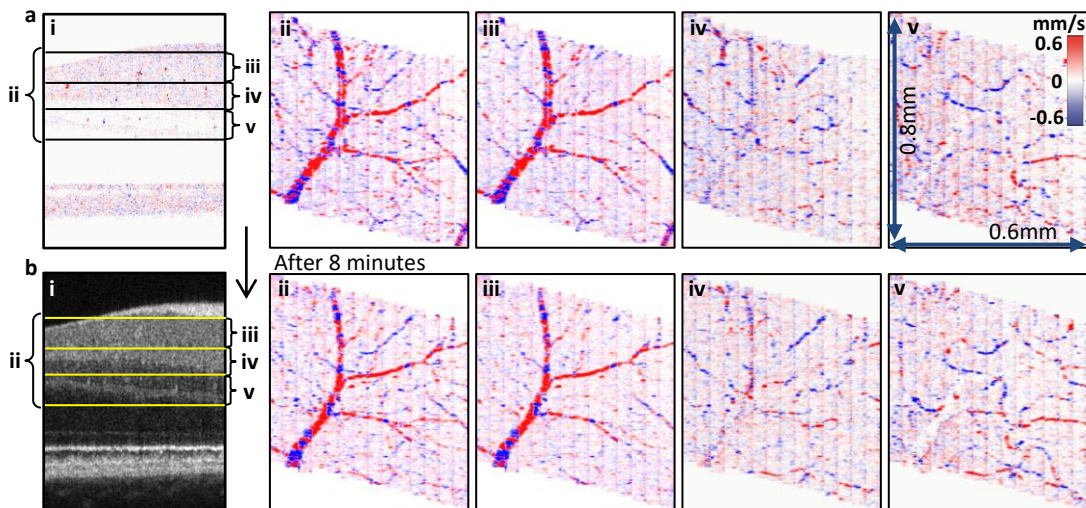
Blood flow velocity maps generated with joint spectral and time-domain OCT method. ii – v. *En face* projection images showing axial blood flow velocity component in the vessels located in retinal anatomical layers, indicated in cross sectional Doppler OCT image (ai) and structural OCT image (bi). ii. *En face* projection of the inner retinal layers. iii. Projections of the vasculature located in the ganglion cell layer. iv. Inner capillary plexus. v. Outer capillary plexus. Rows a and b show the same area in the retina imaged at time points separated by 8 minutes. Repeatability of flow velocities is visible in each pair of the *en face* images.
